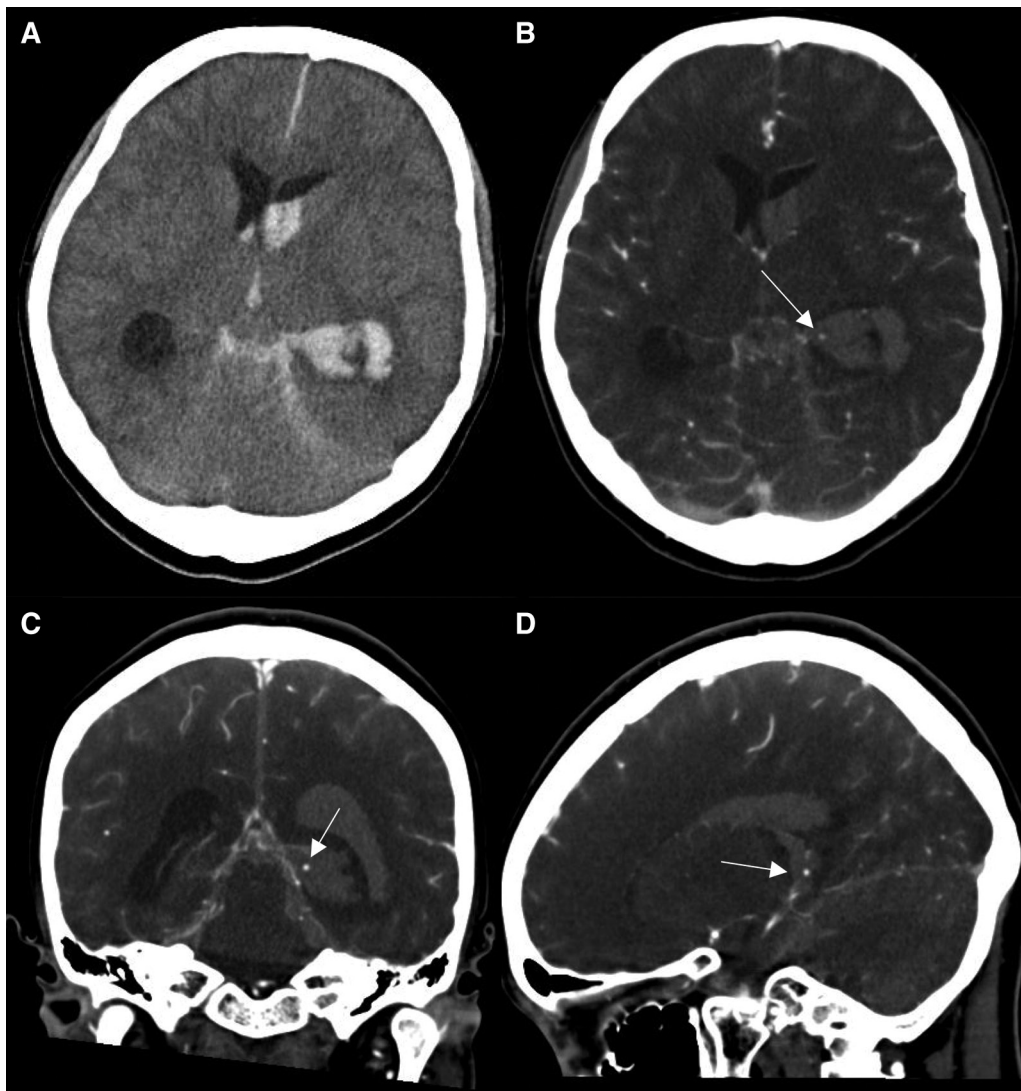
CT and CTA on admission. (A) CT shows subarachnoid hemorrhage and intraventricular hemorrhage, with a thick hematoma around the choroidal fissure. (B–D) CTA. The point of rupture is visualized as a high-density spot (white arrow).
